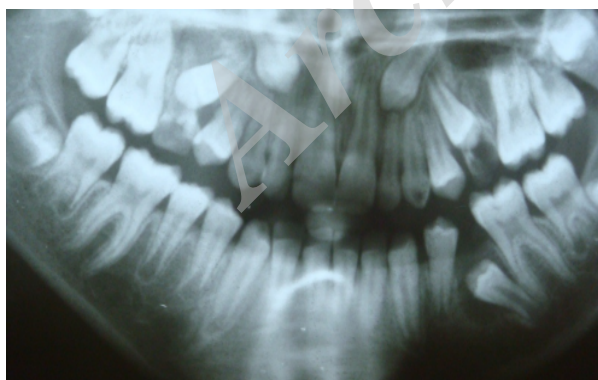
Panoramic radiograph taken 16 months after extraction of mandibular left primary second molar
